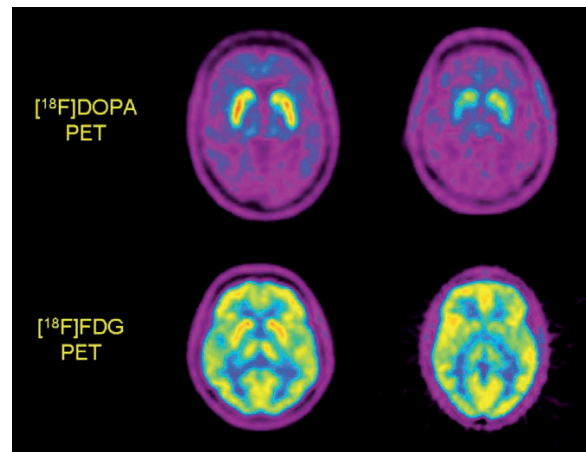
Transverse PET slices at the level of the striatum. Upper panel: left: normal  $^{18}\text{F}$ -DOPA uptake in the striatum in a patient suffering from essential tremor; right: reduced striatal uptake (particularly in posterior putamen) in a hemiparkinsonian PD patient (with motor signs on left side of body). Lower panel: note the lower striatal  $^{18}\text{F}$ -FDG uptake in the striatum of an MSA patient (right side) than in a patient suffering from PD (left). Images courtesy of L.K. Teune and K.L. Leenders, Department of Neurology, University Medical Center Groningen, Groningen, The Netherlands
